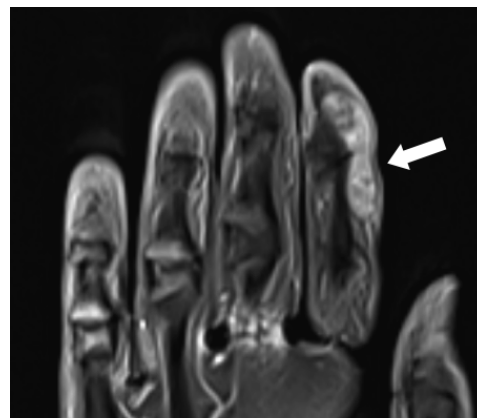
Magnetic resonance image of the left hand showing a solid soft tissue lesion with moderate enhancement post-contrast
